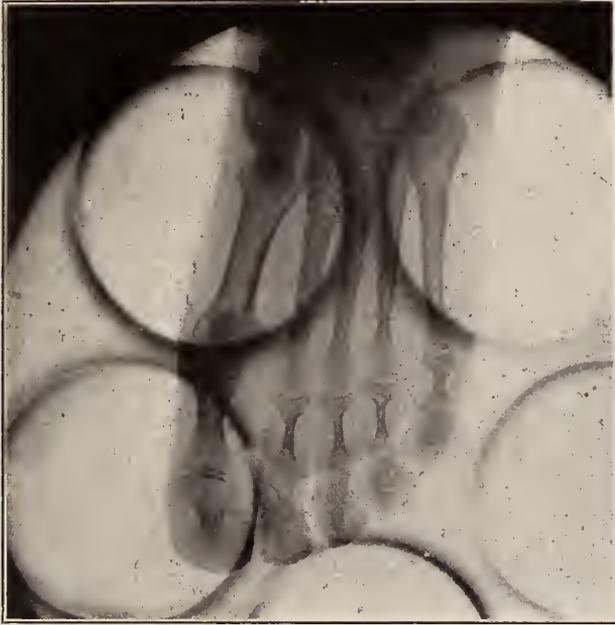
Radiograph made with Tousey's (multiple trumpet) radiating cellular diaphragm, January 8, 1908 (pat. ent. of Dr. George A. Dixon). Showed that no portion of a needle remained in the foot.
